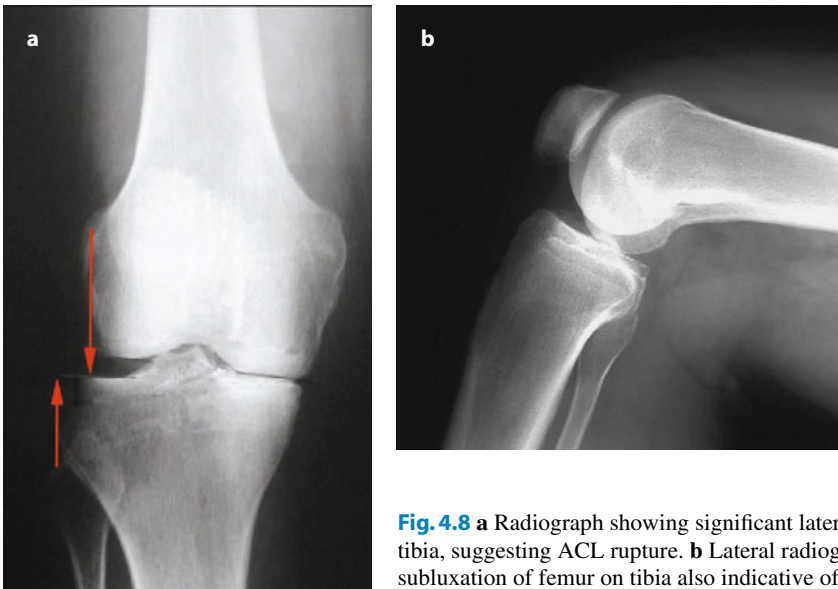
a Radiograph showing significant lateral subluxation of the tibia, suggesting ACL rupture. b Lateral radiograph showing posterior subluxation of femur on tibia also indicative of ACL rupture
